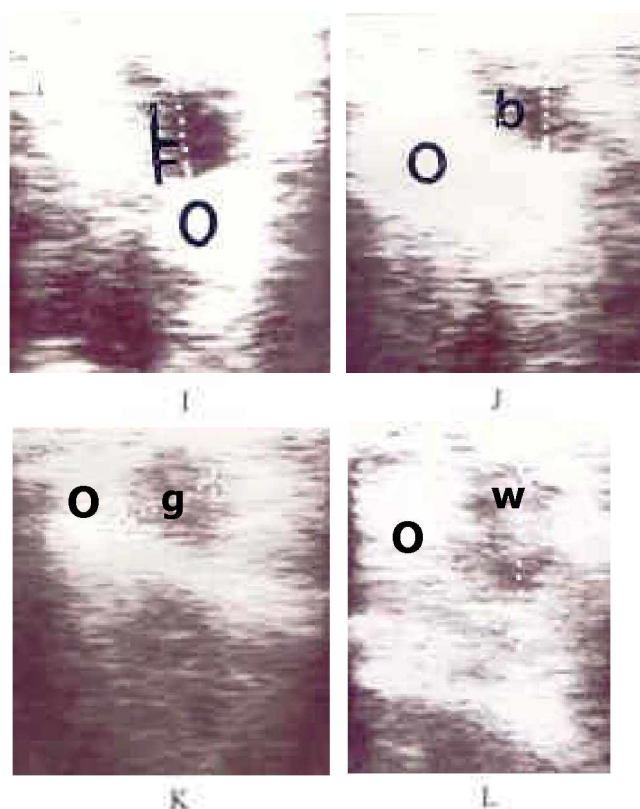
(A to H). Ultrasonographically, the tubular genitalia of buffaloes at estrus appeared as heterogeneous gray shades reflecting development of edema around the nonechogenic (black) central area representing the lumen. During met estrus heterogeneous gray shades were reduced indicating reduction in edema. The image was homogeneous gray without edematous development during mid and late diestrus.
